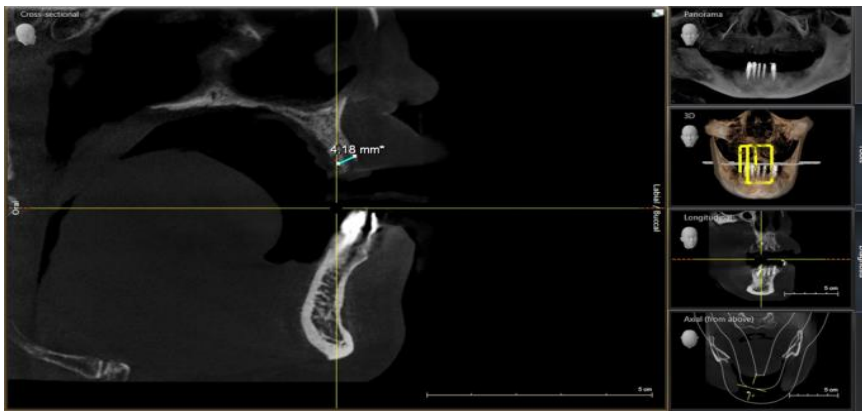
preoperative Cone Beam CT Scan showing the bone thickness on 12.
